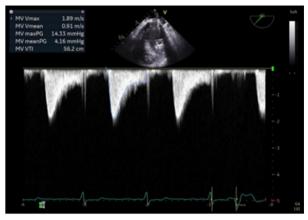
Post-procedure transesophageal echocardiogram: Continuous wave inflow Doppler of mitral valve postdeployment showing resolution of severe stenosis and an improved mean gradient of 4.16 mmHg.
